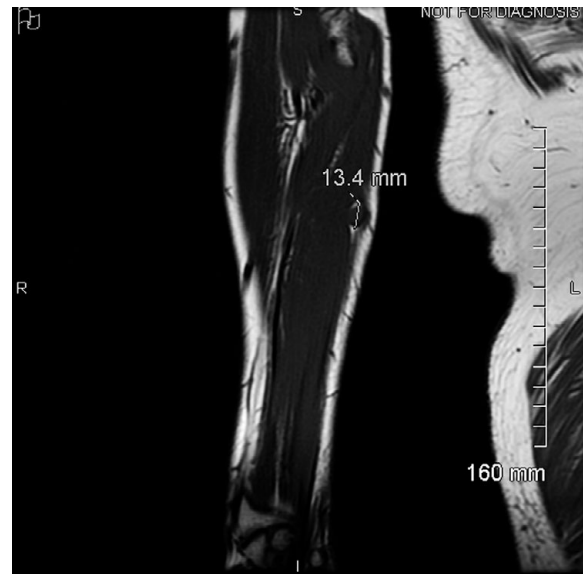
MRI of the forearm
